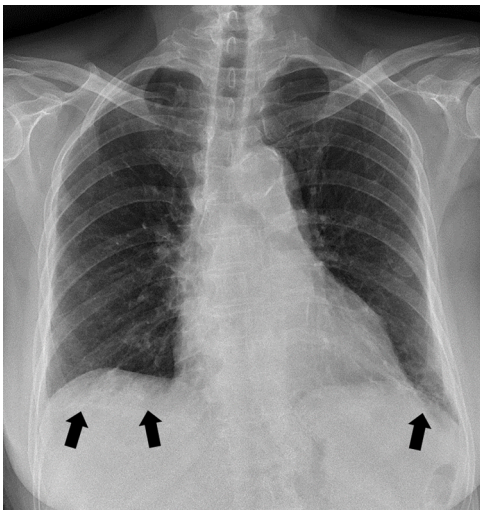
A posteroanterior chest radiograph after anti-mycobacterial treatment. Multiple consolidations and ground-glass opacities were improved. Reticular opacities were noted in both lower lung zones (arrows).
